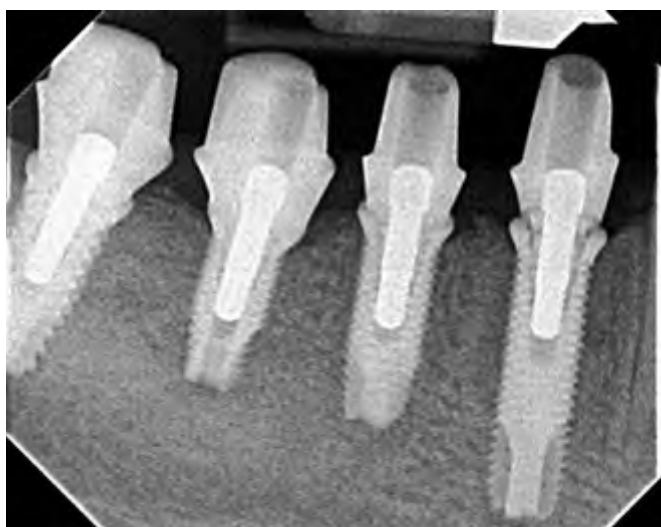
Radiograph with the four abutments in place demonstrated that the abutments were seated correctly onto their respective implant restorative platforms. An ill-fitting abutment would be identified by a radiolucent space between an abutment and an implant restorative platform. All of the abutments were made consistent with platform switching.
